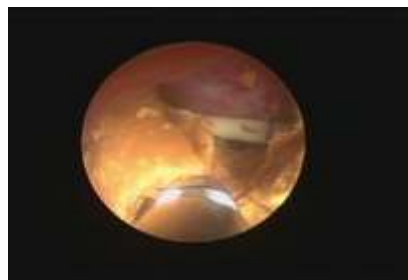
Nephroscopic view of a renal pelvic stone, which has been fragmented with ultrasonic probe. Note the ureteric catheter seen in the place.
